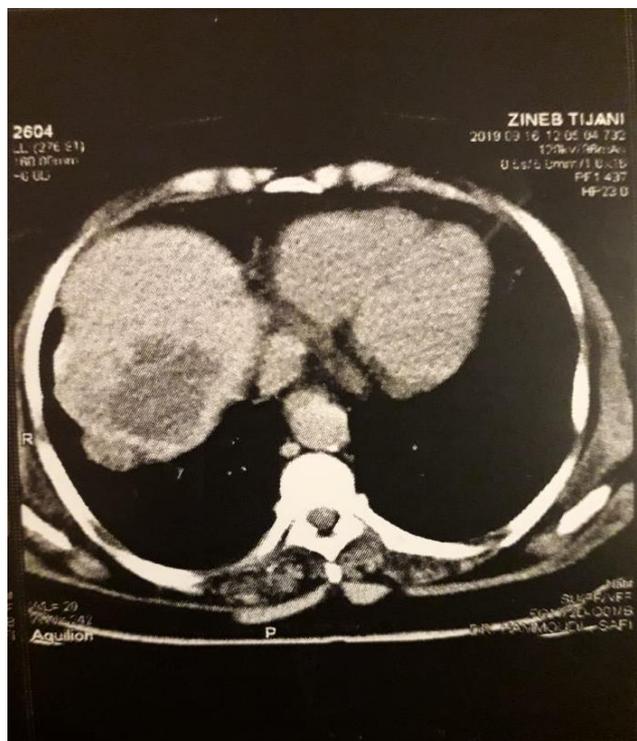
Abdominal CT showing a hydatid cyst of segment VII of the Liver
